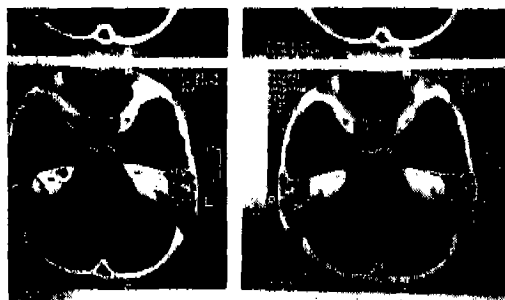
High resolution Computerized Tomography (CT) Scanning of the petrous bone using 1 mm axial cuts revealed bilateral dilatation of the vestibular Aqueducts. The cochleas, semicircular canals and tympanic cavities together with the rest of the temporal bone were normal.
